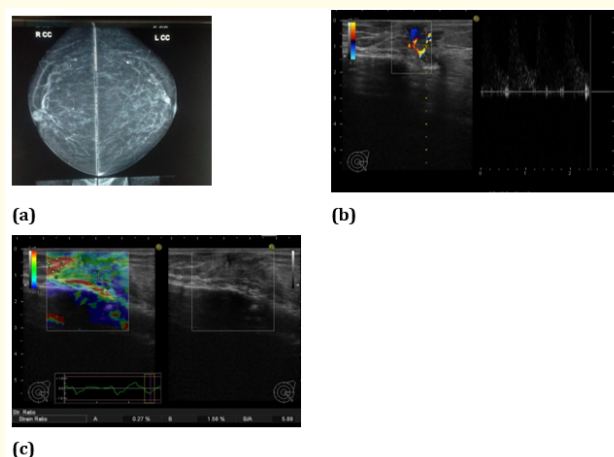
67 years old female patient (known case of left parasternal malignant breast mass on chemotherapy) (a) mammogram (CC view) could not assessed the lesion (b) conventional US showed hypo-echoic lesion noted at the parasternal region with irregular borders and detected vascularity on color Doppler. (c) elastography showed lesion with score 3 (the lesion produced a small central blue area that was surrounded by a green peripheral color.) and strain ratio 5.8
